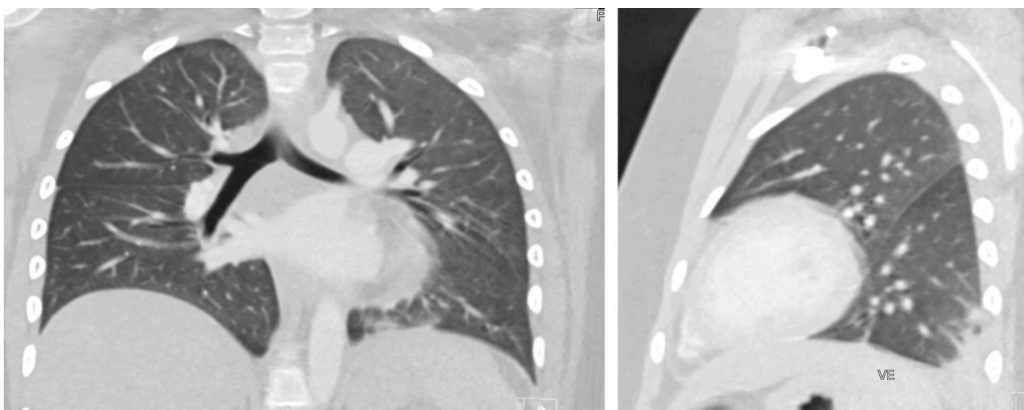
CT thorax with intravenous contrast shows a basilar opacity and modest ground-glass opacities in the left lung, a clear right lung, and no pulmonary emboli.
